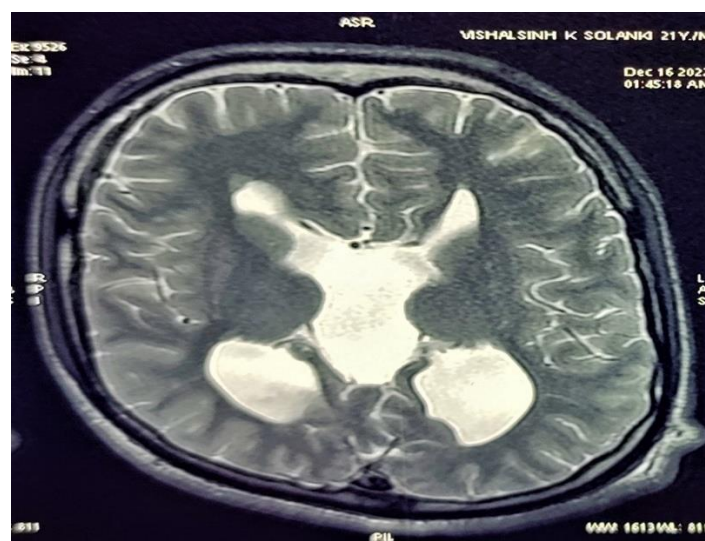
MRI Brain (T2W imaging) horizontal cut showing absence of interventricular septum and dilated occipital horns (P/A >3) with "Racing car" appearance
